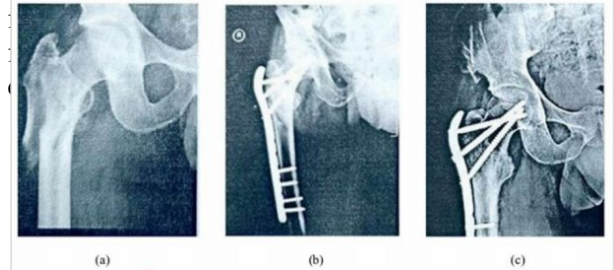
(a) Preoperative X-ray of the hip A/P view showing unstable intertrochanteric fracture. (b) postoperative X-ray of the hip A/P view showing ORIF with PFLCP. (c) After 6 months of operation, the X-ray showed good union
